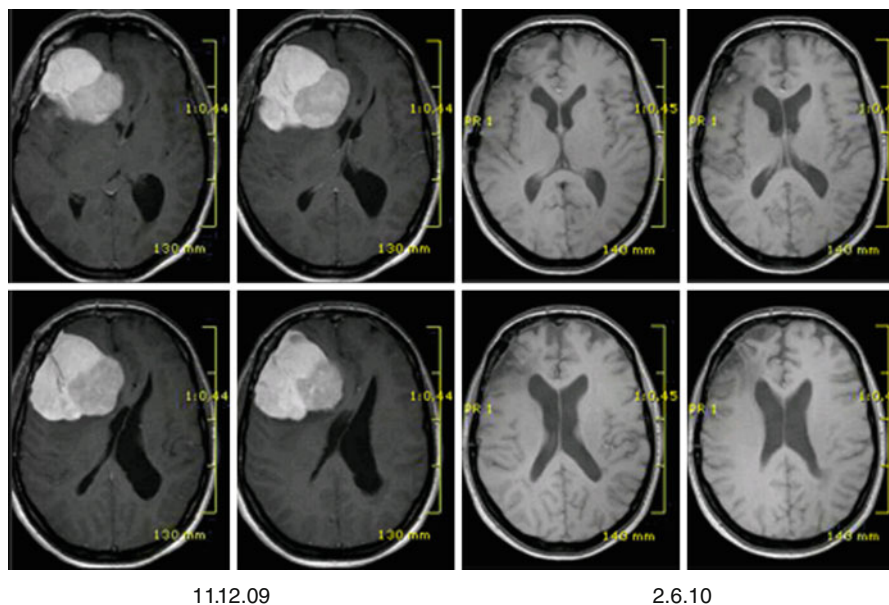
Severe long-standing misdiagnosed neuropsychological problems in a female patient improve only slowly postoperatively, although the patient had understood how well she was “objectively” doing. (a) Preop MRI; (b) postop MRI scan shows nearly normal brain with only minor scar right frontal region, 6 months postop
